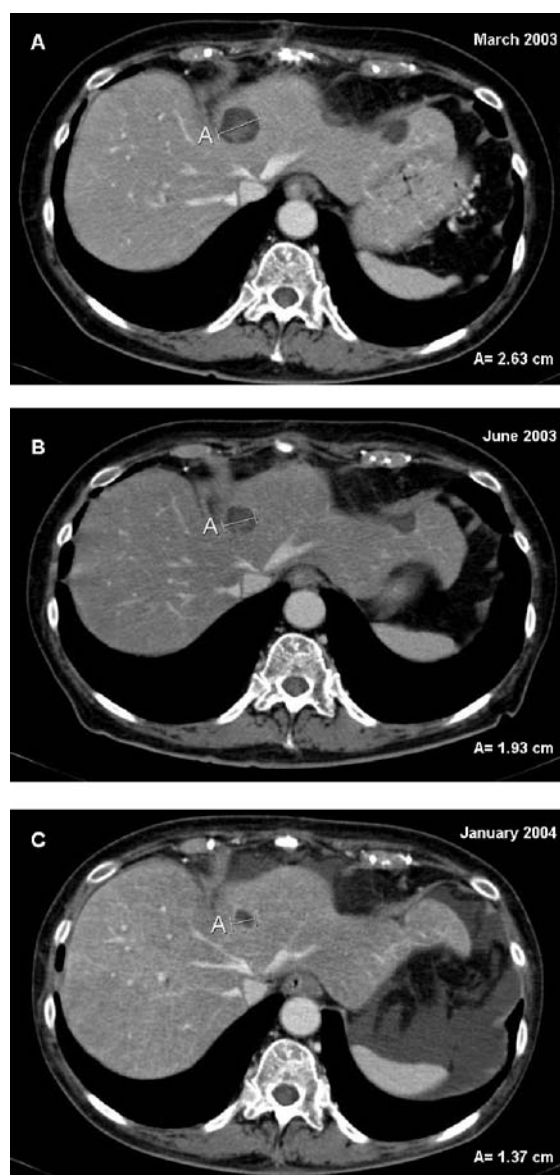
CT scans of a representative patient with WD-NECs undergoing octreotide LAR plus IFN- α -2b therapy. Panel A shows pre-treatment assessment; panels B and C show tumour regression at 3 and 12 months, respectively.
